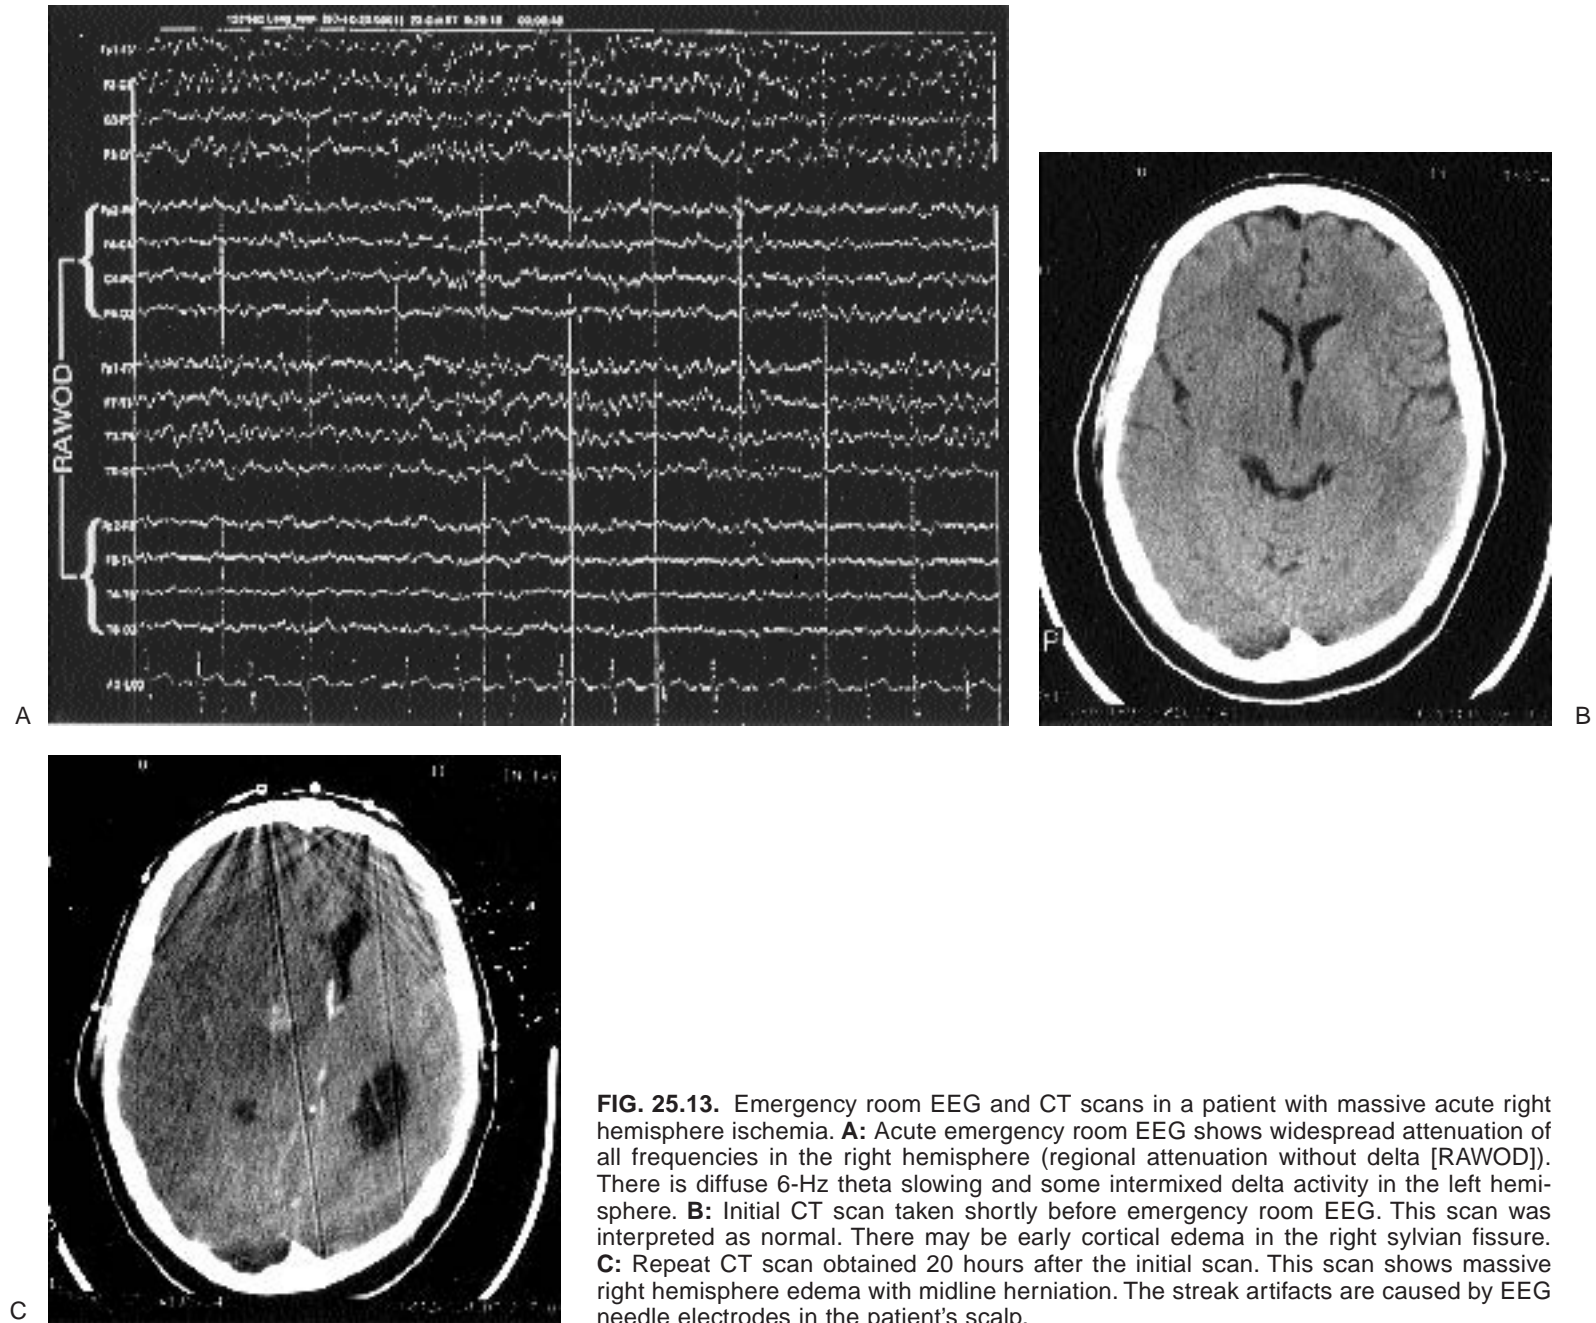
Emergency room EEG and CT scans in a patient with massive acute right hemisphere ischemia. A: Acute emergency room EEG shows widespread attenuation of all frequencies in the right hemisphere (regional attenuation without delta [RAWOD]). There is diffuse 6-Hz theta slowing and some intermixed delta activity in the left hemisphere. B: Initial CT scan taken shortly before emergency room EEG. This scan was interpreted as normal. There may be early cortical edema in the right sylvian fissure. C: Repeat CT scan obtained 20 hours after the initial scan. This scan shows massive right hemisphere edema with midline herniation. The streak artifacts are caused by EEG needle electrodes in the patient's scalp.
